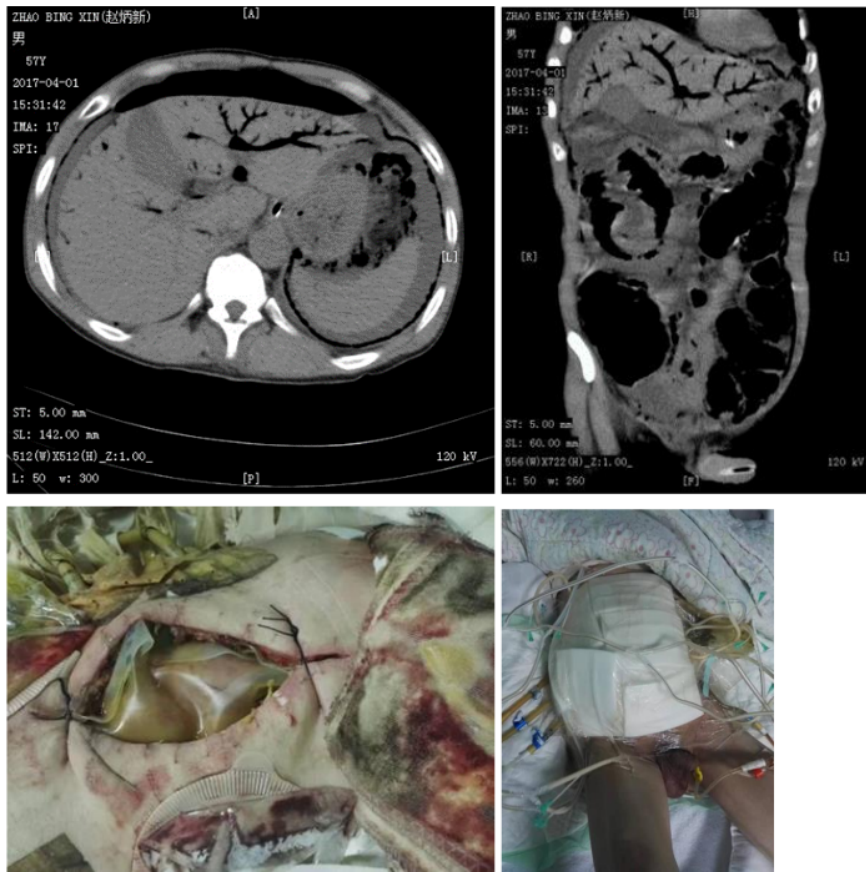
Image examination and treatment. A: Preoperative computed tomography (CT) showing pneumoperitoneum and portal venous gas; B: Coronal view of abdominal CT showing extensive portal venous gas; C: Bogota bag before the second surgery; D: Vacuum sealing drainage.
